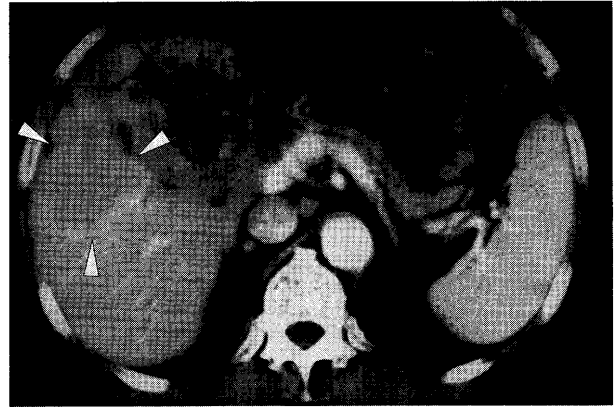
Follow-up CT performed on 6 months after liver biopsy showed the mass initially 7.5×8.5 cm in size, was decreased to 5.5×6 cm.
